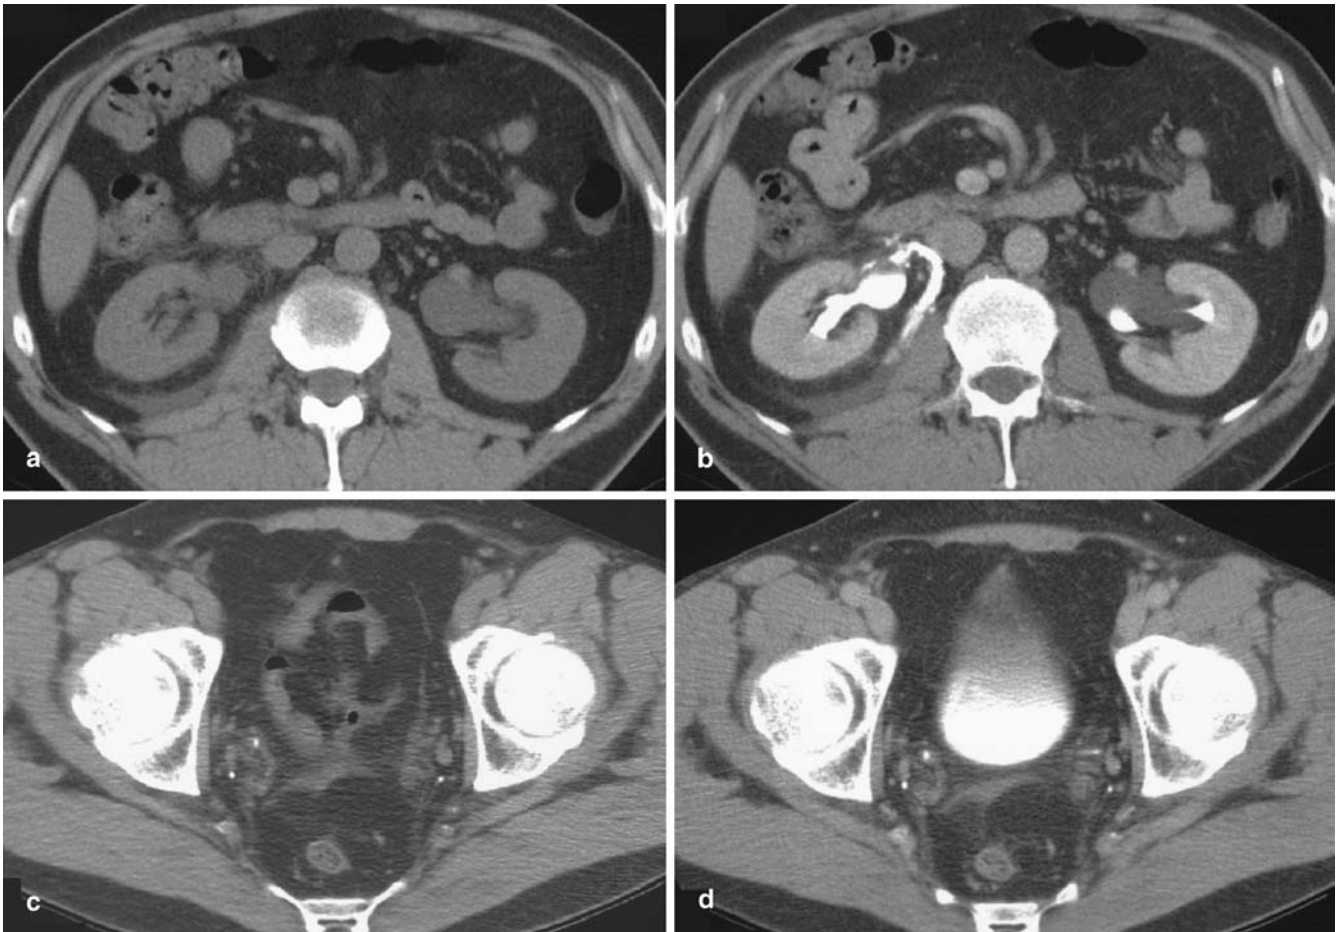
a Perinephric stranding surrounding the right kidney with fluid collection from the right sinus to the perinephric space posteriorly (forniceal rupture) and subtle dilated extrarenal pelvis. Renal sinus cysts on the left side which could be misdiagnosed as dilated pelvis, but there is no stranding. b Contrast material has been given because of a suspicious complex cyst on the right upper pole which turned out to be a simple cyst (not shown). These films confirm the forniceal rupture and the renal sinus cyst. c In the same patient a stone in the distal right ureter with subtle rim sign is depicted. Two small phleboliths, one on each side of the pelvis (posteriorly). d Postcontrast CT confirms the stone in the right ureter and the phleboliths in the normal small linear distal ureter
